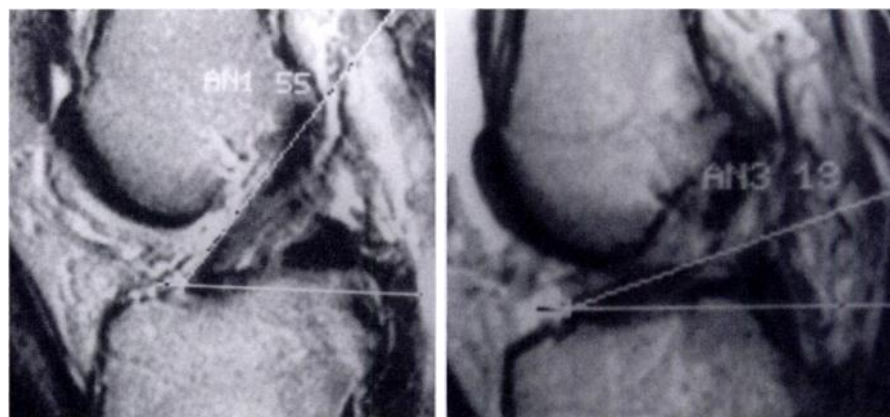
The ACL angle is measured between the anterior surface of the ACL and a reference line parallel to the midlateral tibial plateau. The reference line is drawn on an image through the midlateral tibial plateau and reported on the image showing the ACL. (a) Sagittal (2,100/90) MR image shows ACL angle of 55° (AN1 55) measured in a 55-year-old man with an intact ACL at arthroscopy. (b) Sagittal (2,000/80) MR image shows ACL angle of 19° (AN3 19) measured between the anterior surface of the ACL and a reference line parallel to the lateral tibial plateau in a 35-year-old man with an ACL tear at arthroscopy.
